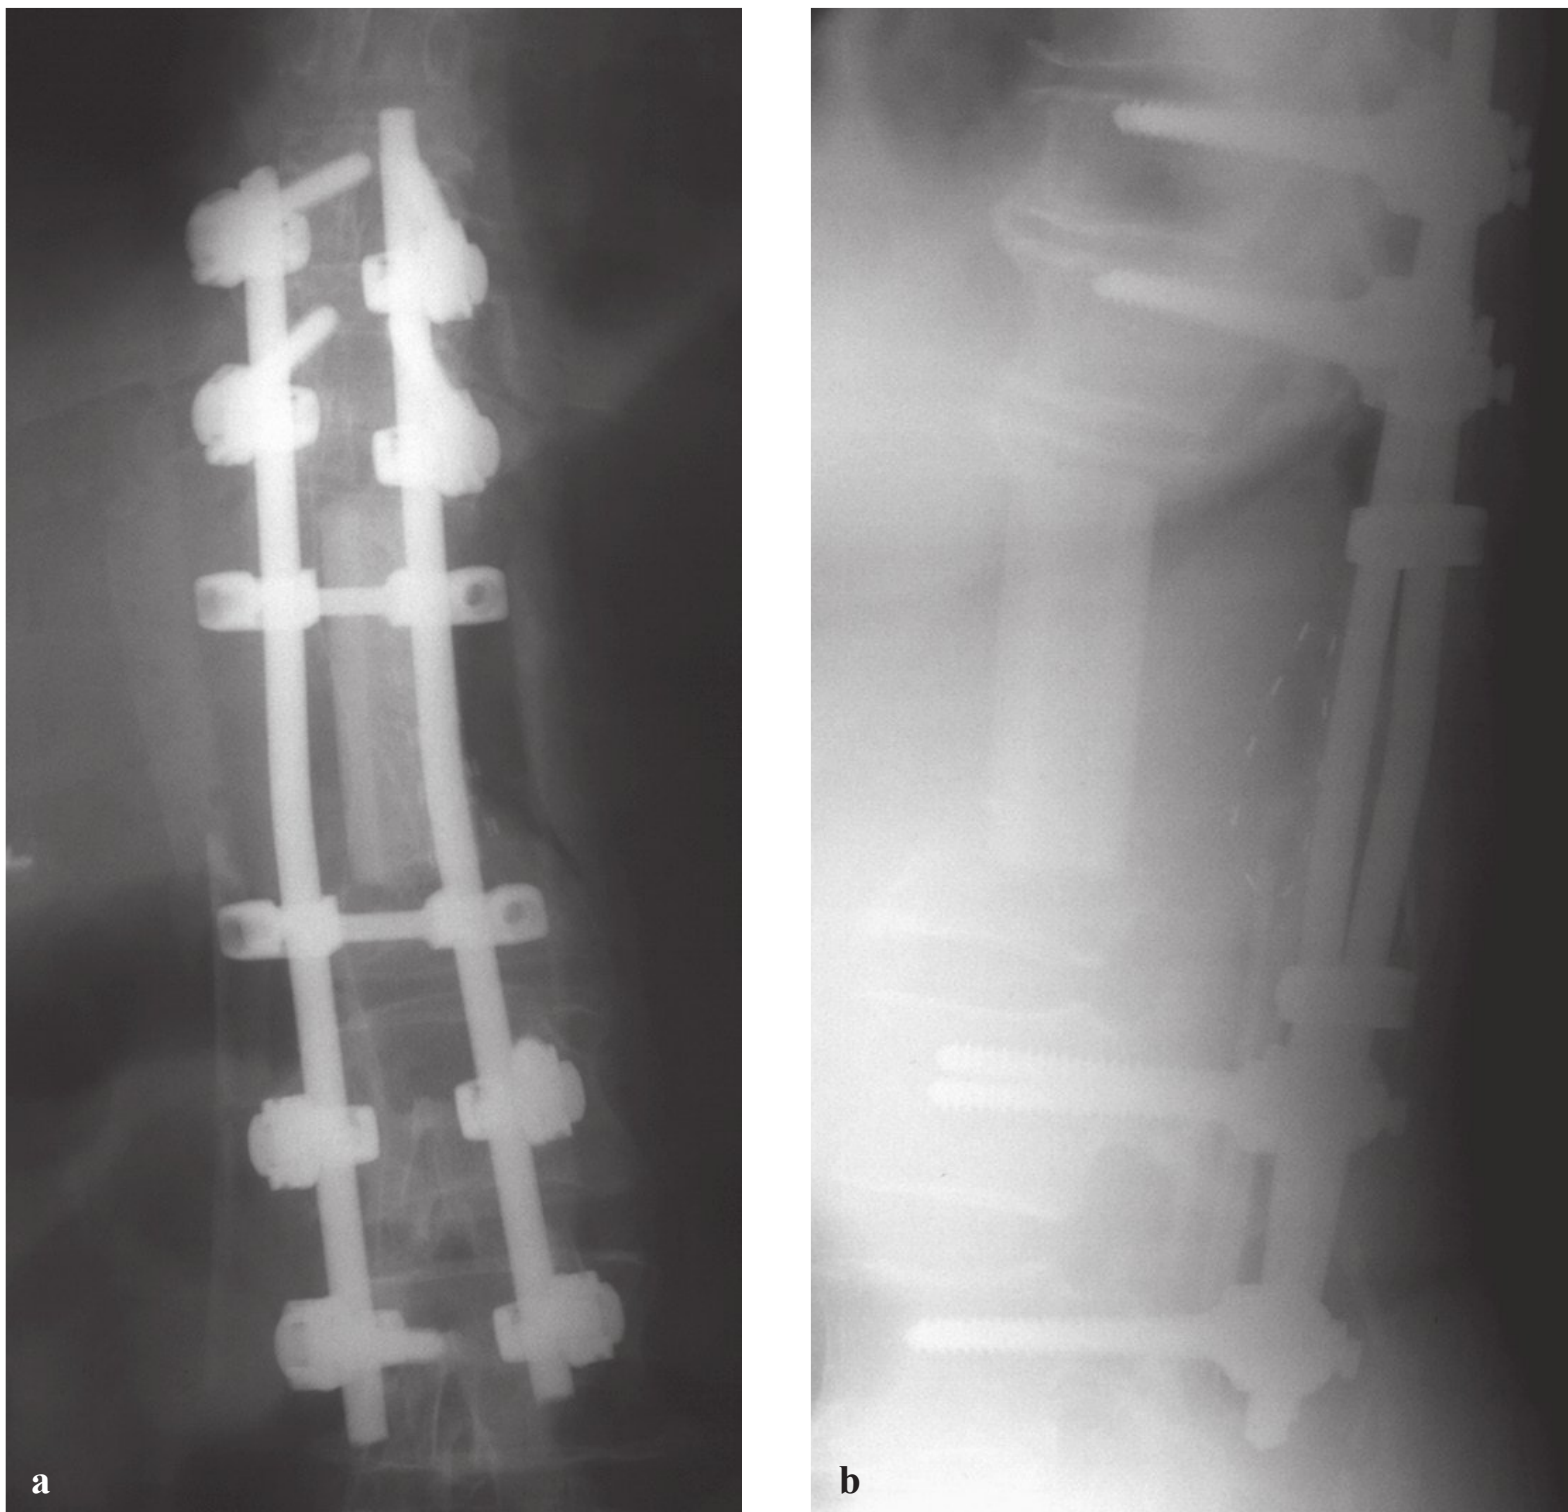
(a,b) Anteroposterior and lateral radiographs following total spondylectomy for a T11 chordoma with spinal instrumentation and graft in position. (From Dickman CA, Fehlings MG, Gokaslan ZL. *Spinal Cord and Spinal Column Tumors*. New York, NY: Thieme Medical Publishers; 2006: Fig. 34.14. Reproduced with permission.)
